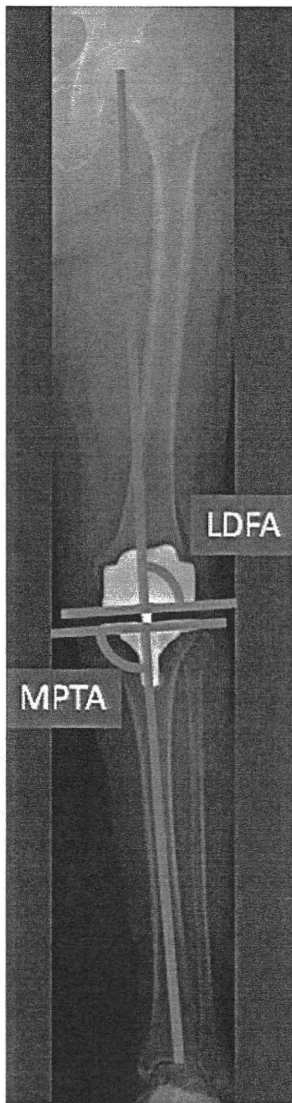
Full-length standing anteroposterior radiograph. The parameters assessed in the frontal plane are *LDFA* lateral distal femur angle and *MPTA* medial proximal tibial angle
